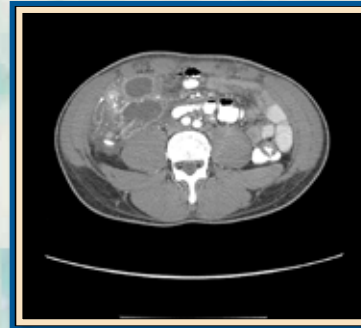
Abdominal CT scan, axial view showing mural thickening involving the ascending colon.
